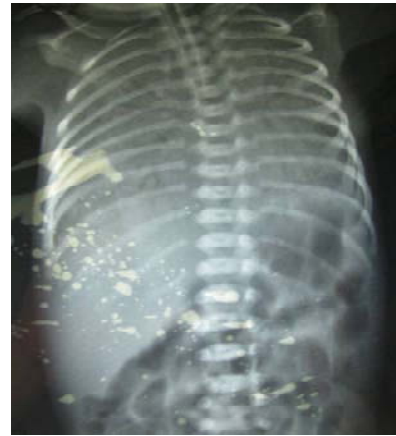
X-Ray chest-showing ground glass appearance of both lung fields before surfactant therapy
